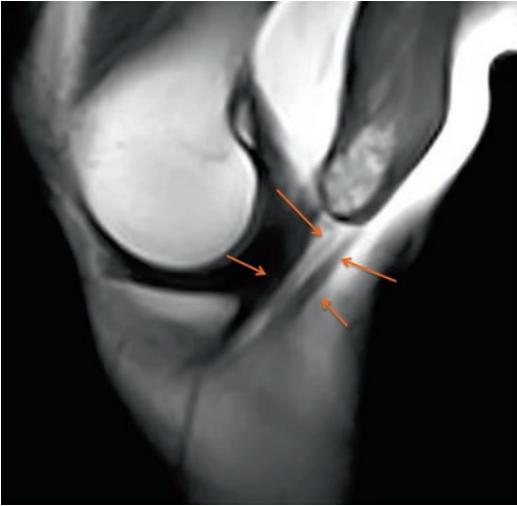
Dynamic MRI demonstrating an extensive haematoma appearing as a cyst at the level of the myotendinous junction of the femoral biceps tendon, without rupture
